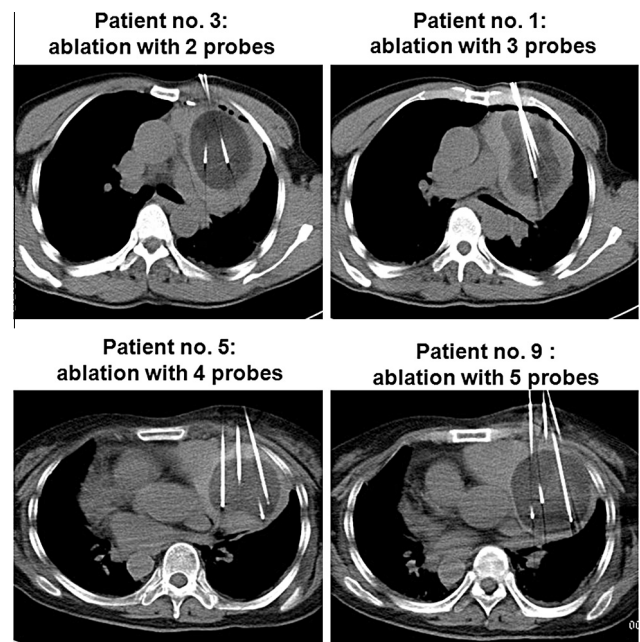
Computed tomography images of four patients who underwent cryosurgery for thymoma. The white lines in the pictures are cryoprobes; the dark areas around the cryoprobes are the location of the thymoma and the ice ball.
